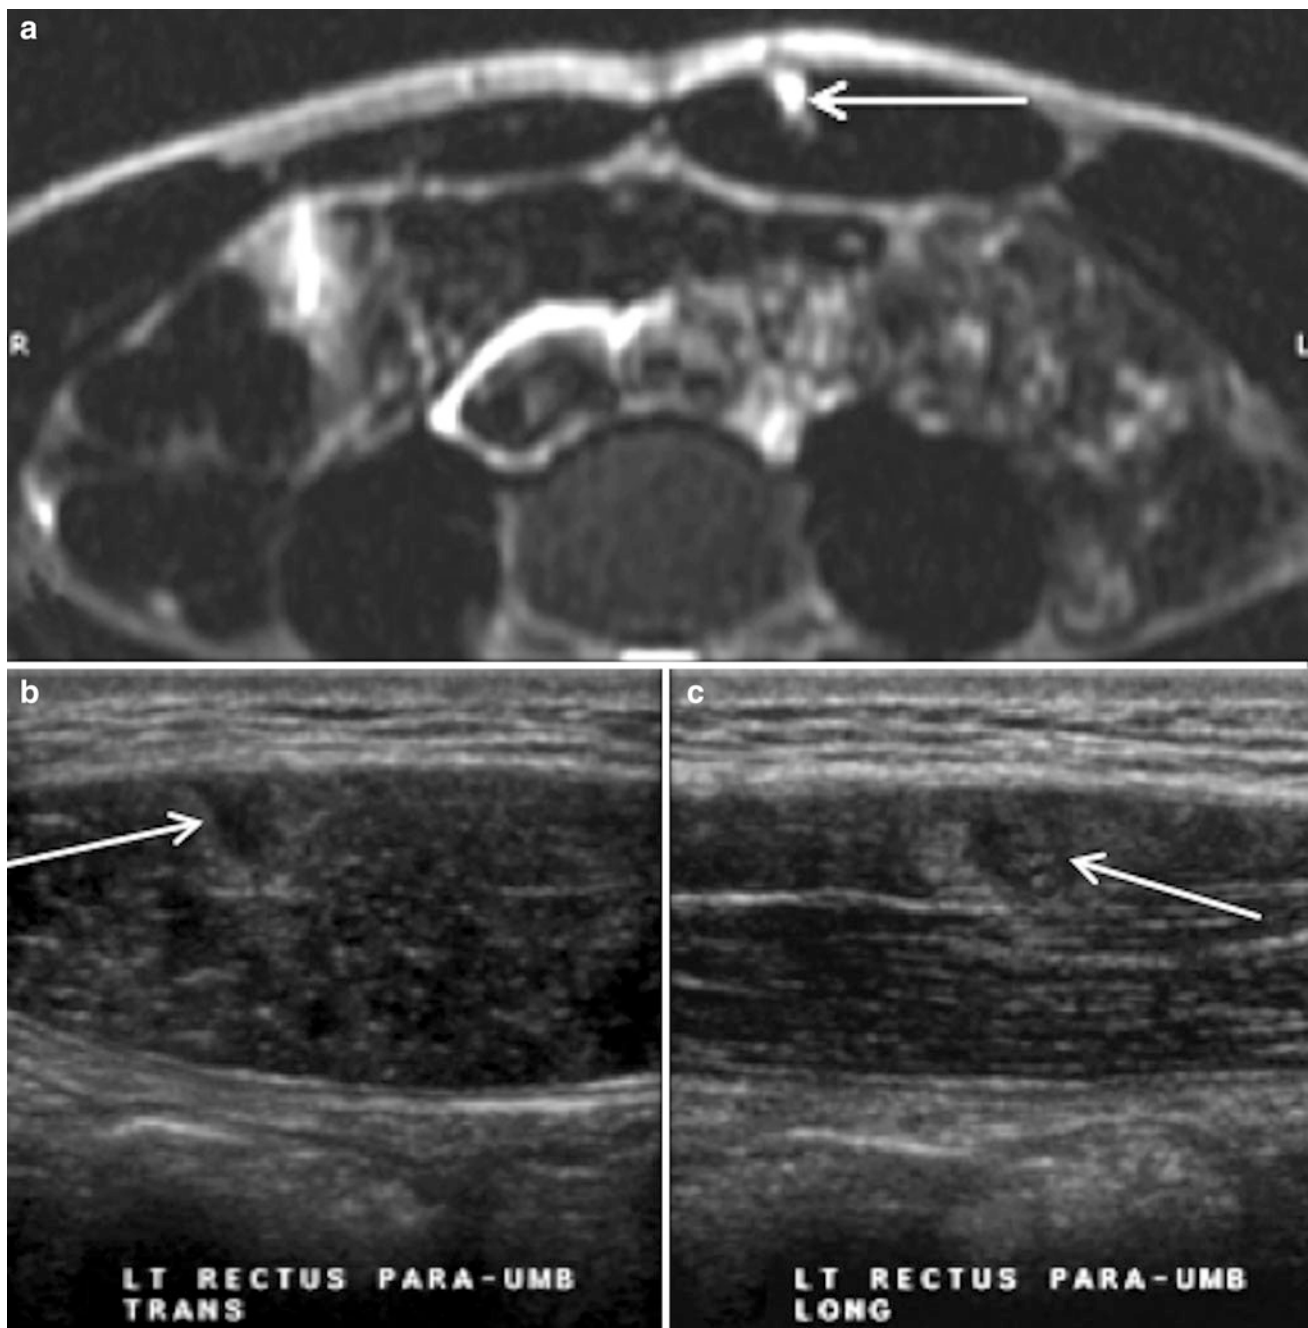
Axial T2-weighted MR image (a) and transverse (b) and longitudinal (c) US images in a professional tennis player with a grade 2 left rectus abdominis muscle injury (arrows). Note the hypertrophy
